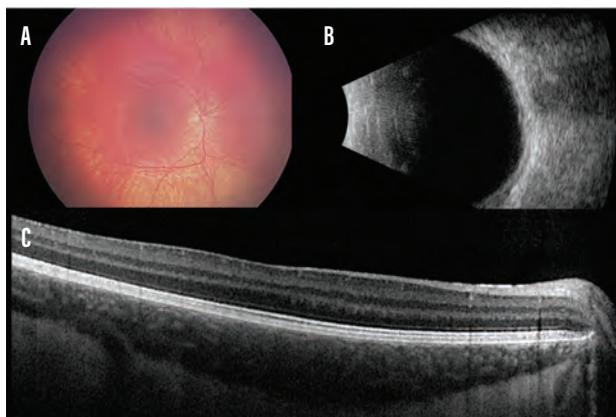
Funduscopy of the right eye showing blonde fundus and prominent choroidal vessels (A), with flat retina on ultrasonography and axial length of 22.3 mm (B). On OCT, there was minimal foveal pit, consistent with fovea plana, and the retinal layers appeared intact (C).
